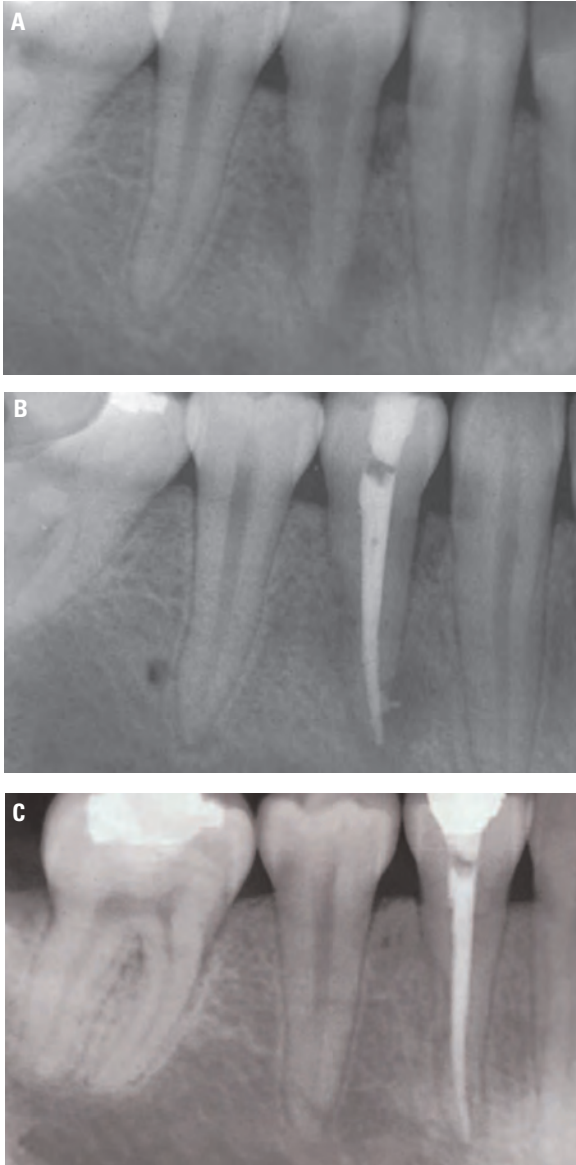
Infection-related (inflammatory) resorption. A, Radiograph taken 2 months after tooth no. 28 was traumatized. Note the resorptive defects in both the root and surrounding bone. Infection-related (inflammatory) resorption. B, Radiograph immediately after the root canal treatment. C, Follow-up radiograph shows healing of the bone and a reestablished periodontal ligament, the expected outcome when treating teeth with infection-related (inflammatory) resorption.
